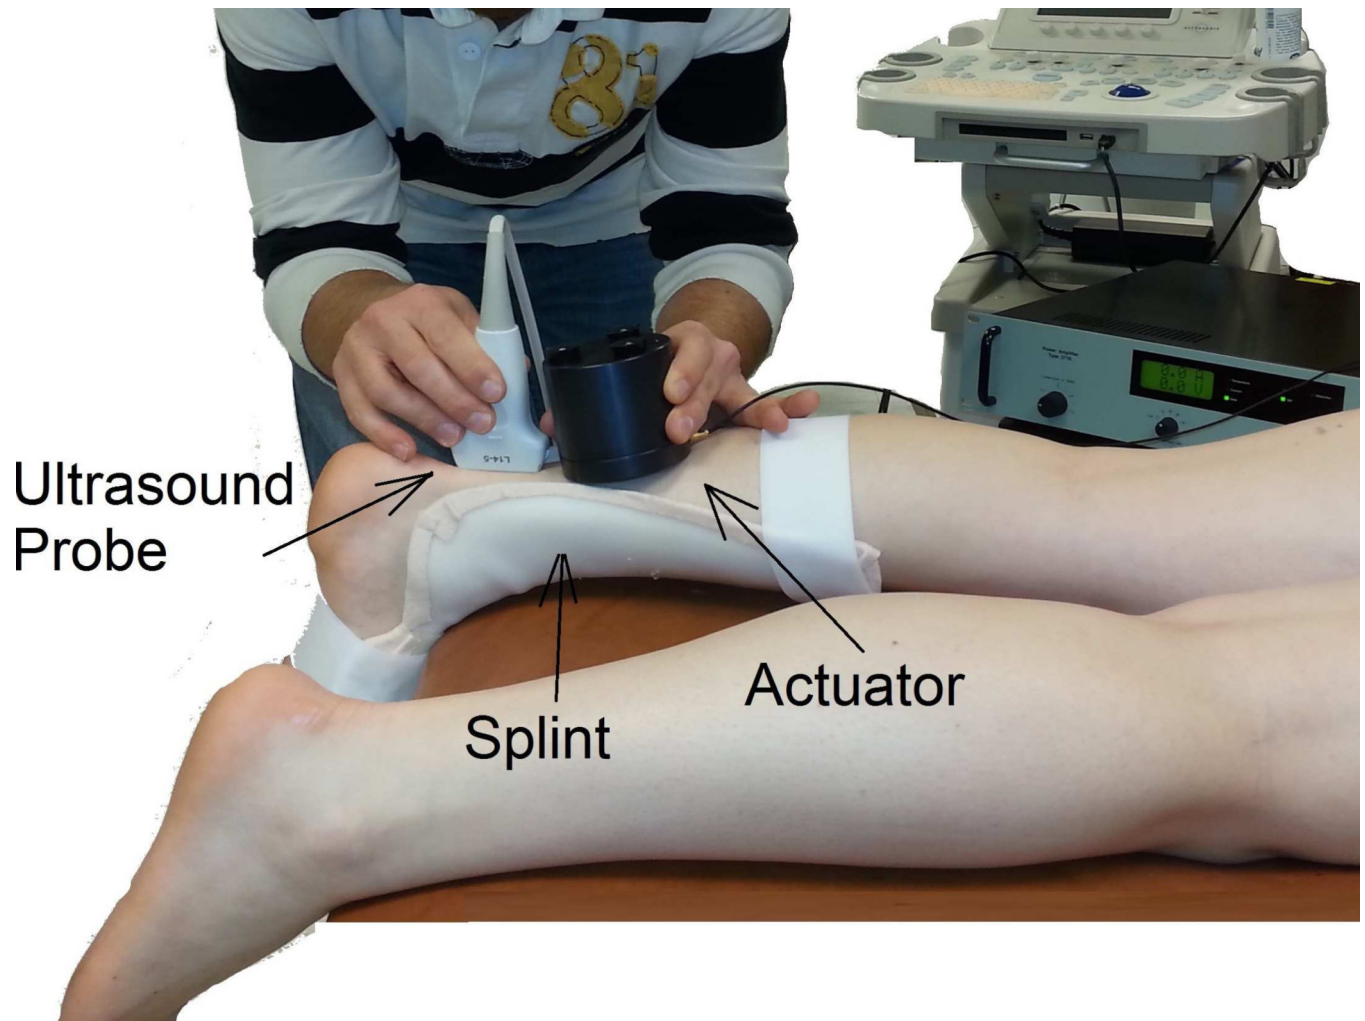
Continuous shear wave elastography set-up consists of a hand-held mechanical actuator that generates shear waves that propagate through the tendon. Shear wave velocity is measured using the proposed ultrasound analysis. A splint is used to keep the ankle at a consistent angle between subjects.
